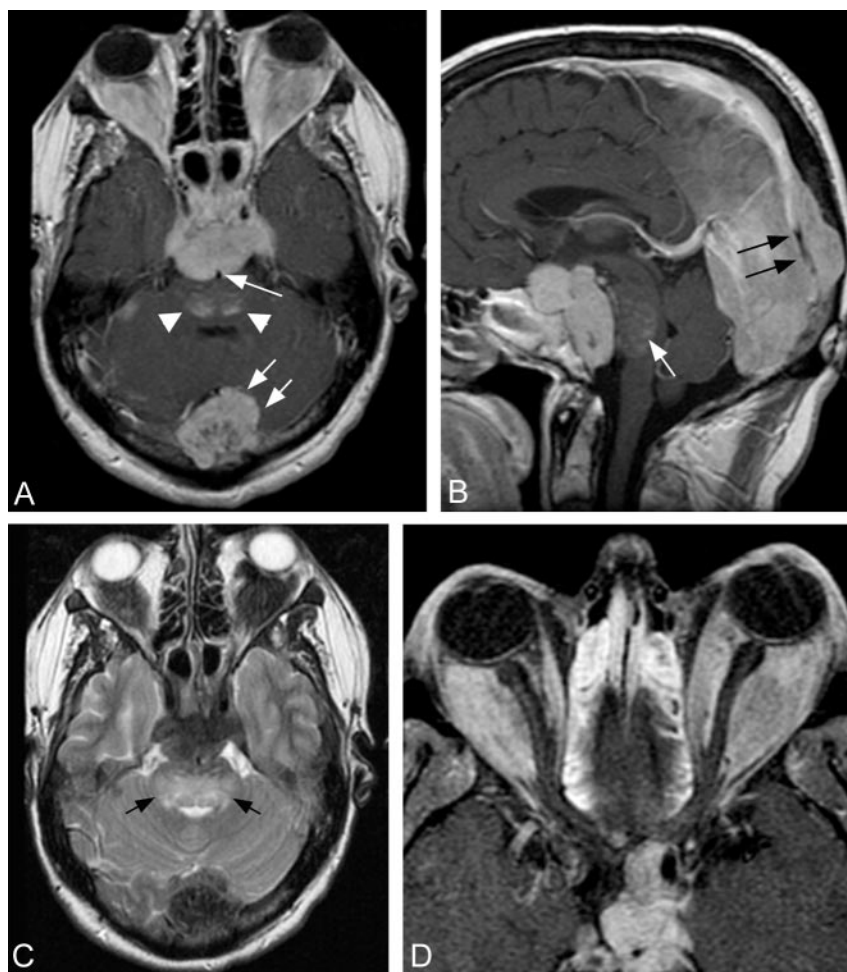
Selected MR images obtained through the brain and orbits 3.0 and 2.5 years after presentation, respectively.
